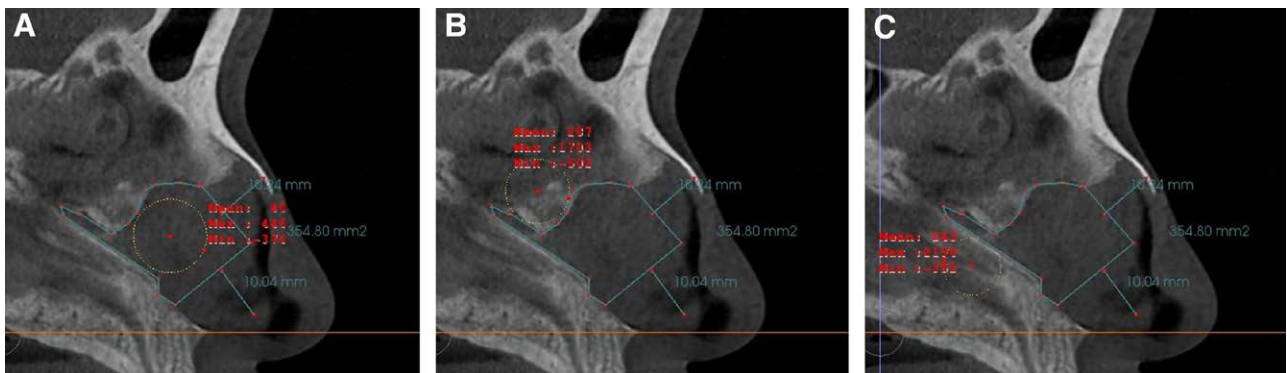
Measurement of HUs of the SCBC using CBCT. A, HU of septal cartilage. B, HU of the perpendicular plate of the ethmoid. C, HU of the vomer.
